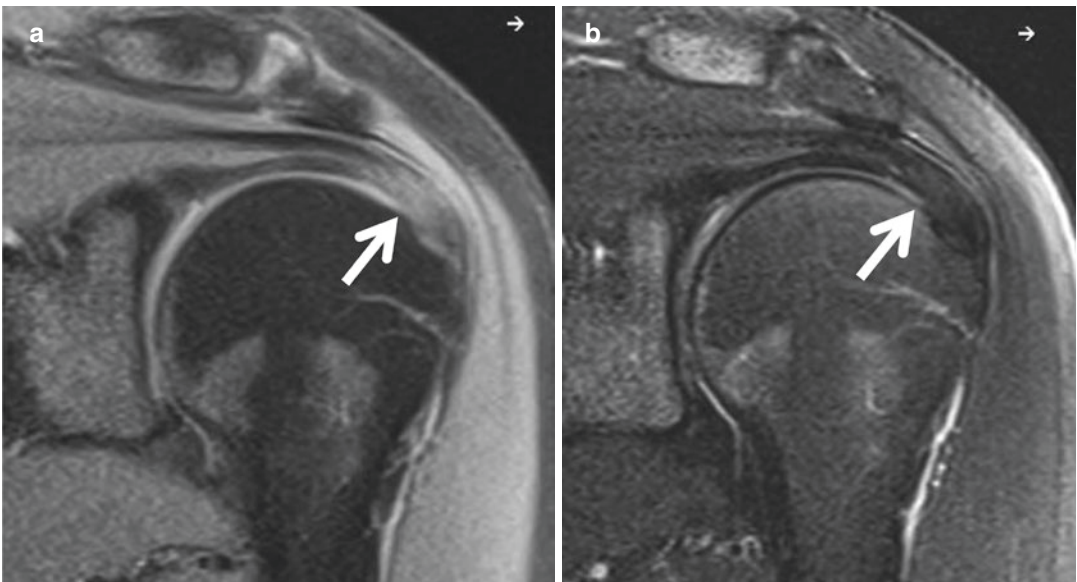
Magic angle artifact. Coronal oblique MR images from the same patient demonstrate (a) increased signal intensity within the supraspinatus tendon (arrows)
